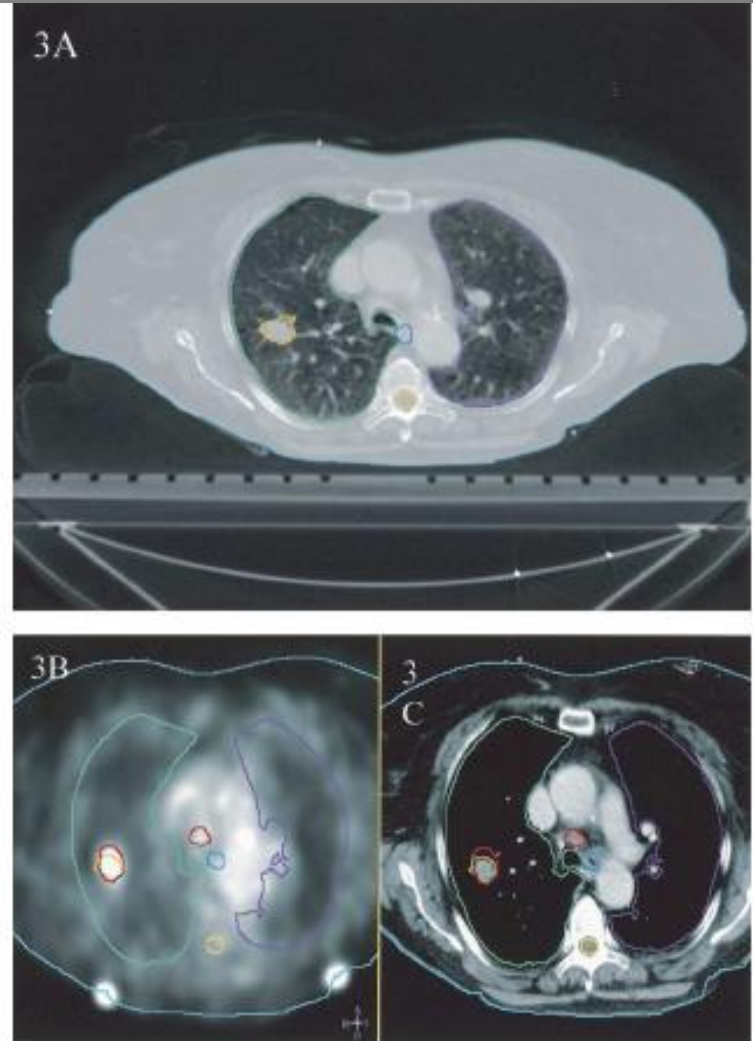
This patient was enrolled in the study with a diagnosis of a T1N0M0, Stage I adenocarcinoma of the lung. The positron emission tomography (PET) scan demonstrated an FDG-avid pretracheal lymph node, changing the clinical stage to T1N2M0, IIIA disease. One can see the fiducial markers containing FDG on the posterior aspect of the patient's contour.
